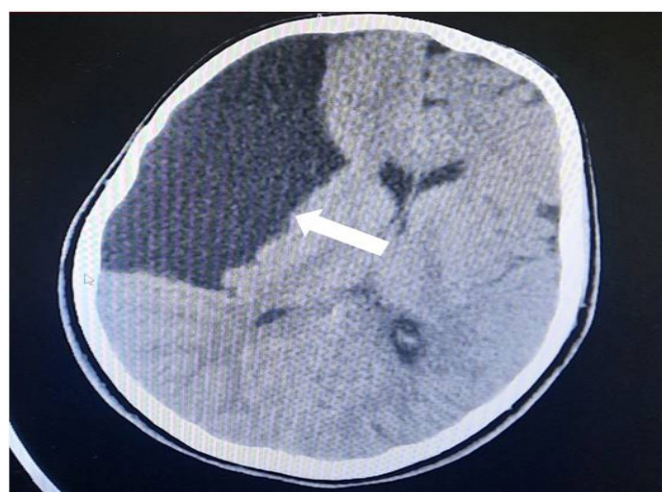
Axial T2-weighted magnetic resonance imaging (MRI) obtained with a 3-mm slice thickness demonstrates a right-sided, well-circumscribed extra-axial lesion exhibiting cerebrospinal fluid-like signal intensity, consistent with an arachnoid cyst (white arrow). The lesion exerts significant mass effect, resulting in a leftward midline shift and effacement of the ipsilateral lateral ventricle, with associated compression of the adjacent cortical and subcortical structures.
